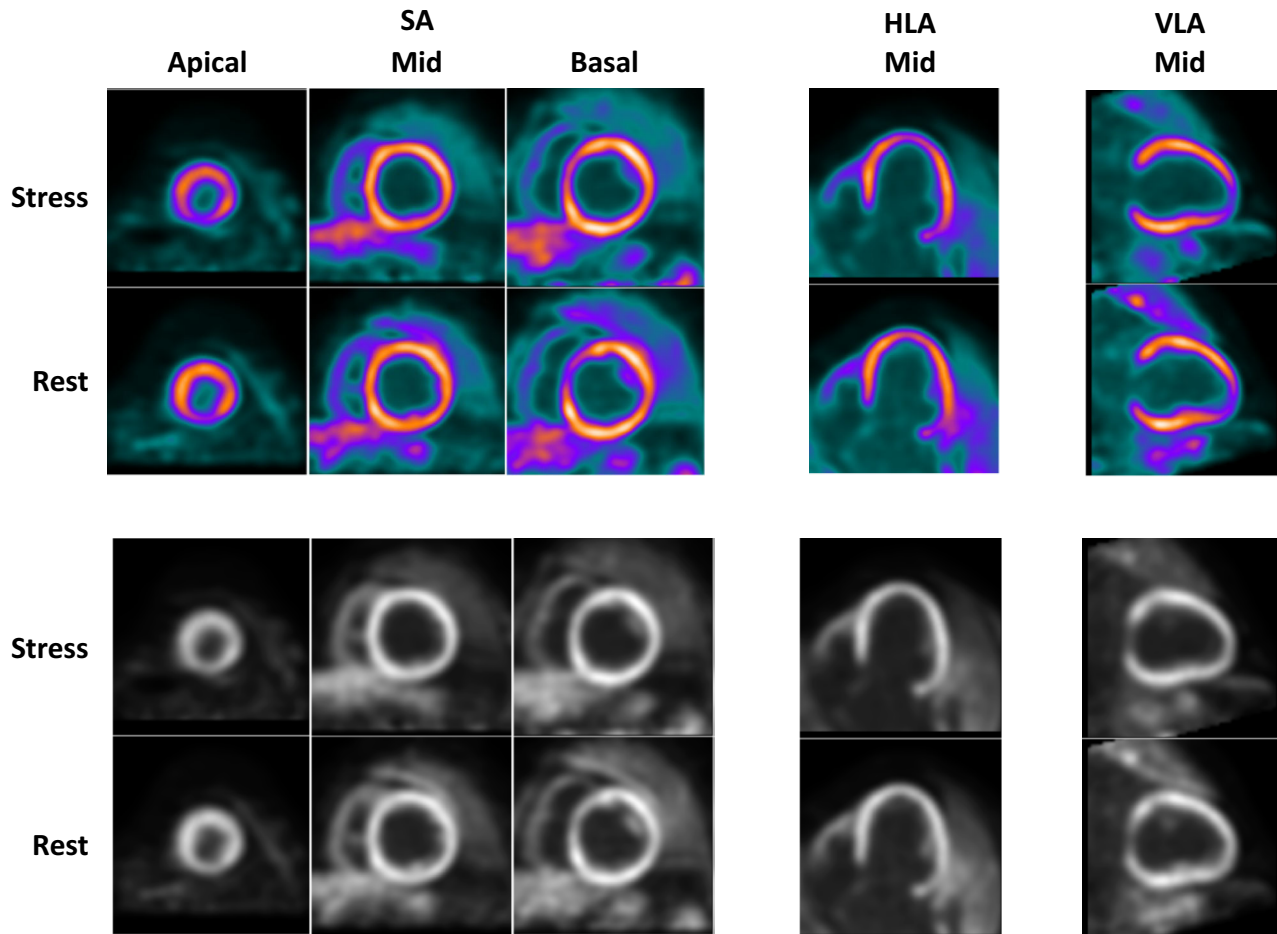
N13-ammonia PET/CT myocardial perfusion scan of a 59-year-old female with an anterior and anteroseptal, partially reversible, as well as completely reversible lateral and anterolateral defects. SA, short axis; HLA, horizontal long axis; VLA, vertical long axis.
